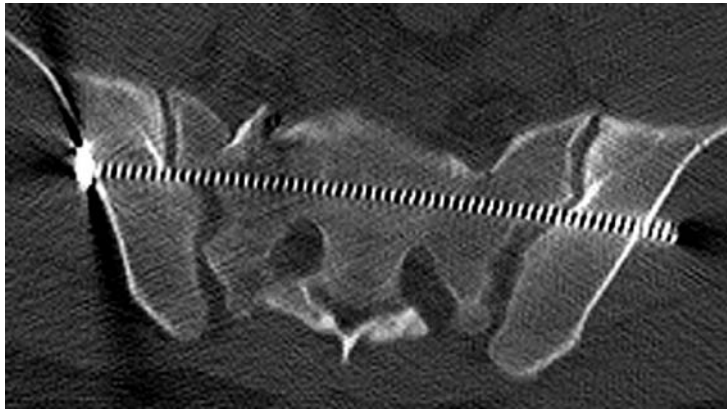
This axial CT image of the second sacral segment reveals the horizontal screw orientation, as well as the longer screw length, and increased alar width for safe screw insertion.
